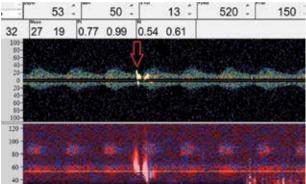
Transcranial Doppler monitoring reveals high intensity transient signal (red arrow)
